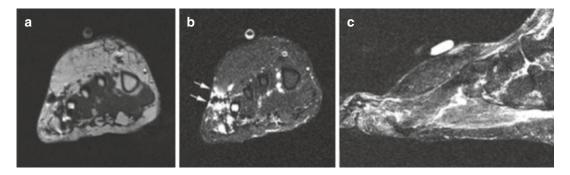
56-year-old woman with haemosiderotic fibrolipomatous tumorsuperficial to the metatarsals. (a) Coronal T1-weighted MR image. (b) Coronal T2-weighted MR image with fat saturation. (c) Sagittal T2-weighted fat-suppressed MR image. The coronal T1-weighted MR image (a) shows a high-signal mass superficial to the metatarsals that is predominantly fat-intense. A coronal T2-weighted fat-suppressed MR image (b) shows a
